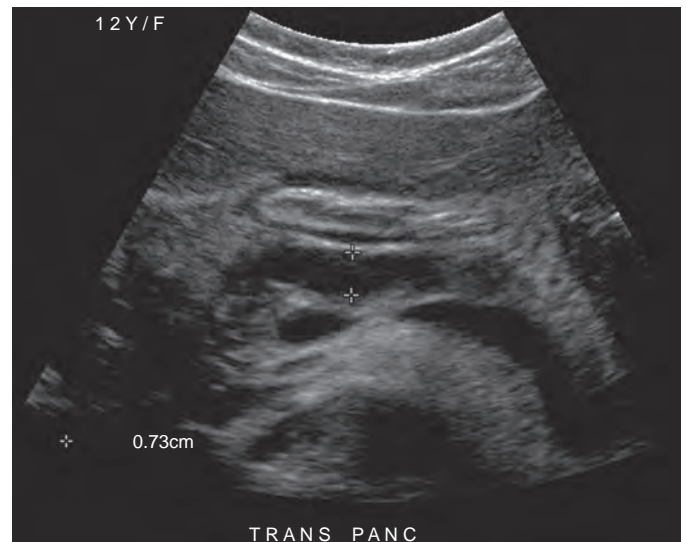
Chronic pancreatitis. The transverse sonographic image of the pancreas reveals dilation of the main pancreatic duct in a 12-year-old girl with chronic pancreatitis.
